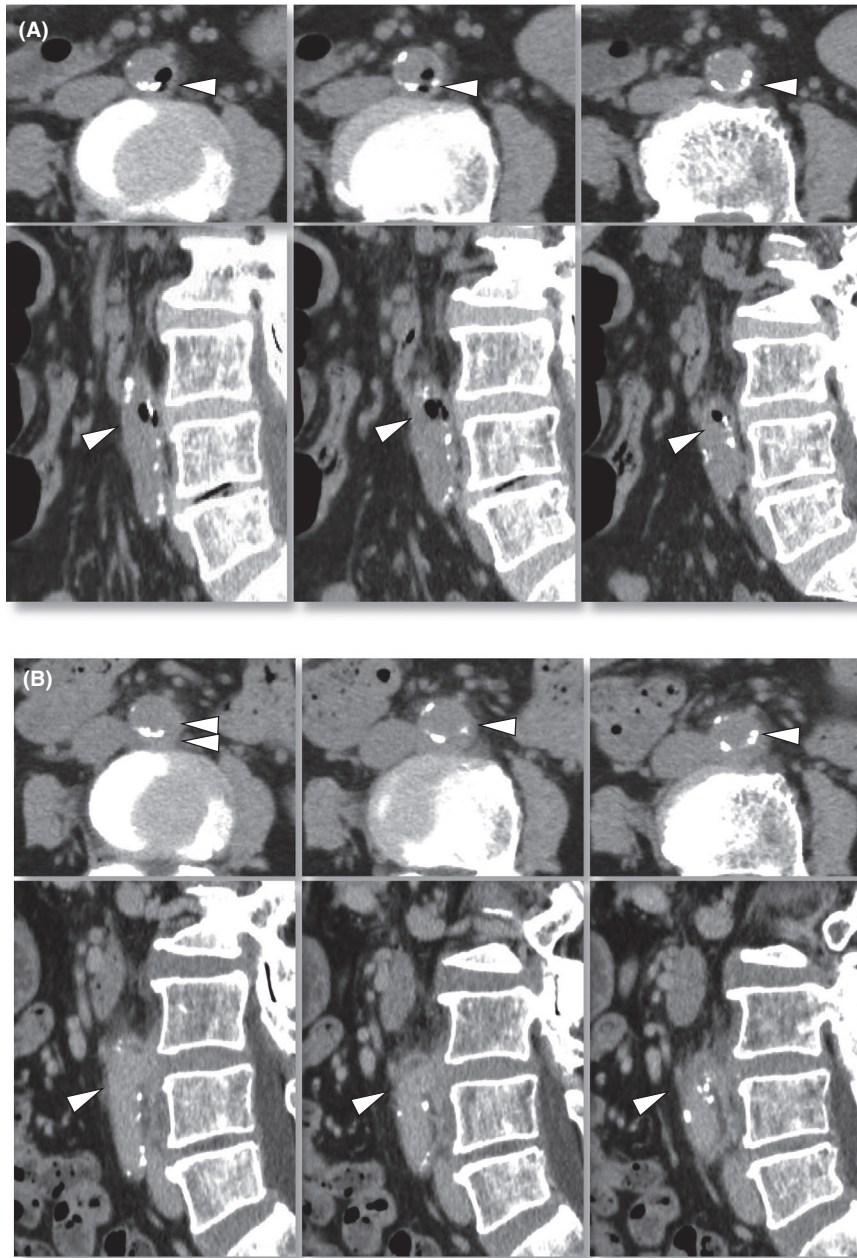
Abdominal computed tomography on admission (A) and on day 11 (B). Air-density spots were found in the aortic wall (A, arrowheads). They later disappeared, and outpouching of the arterial wall emerged at the corresponding site (B)
